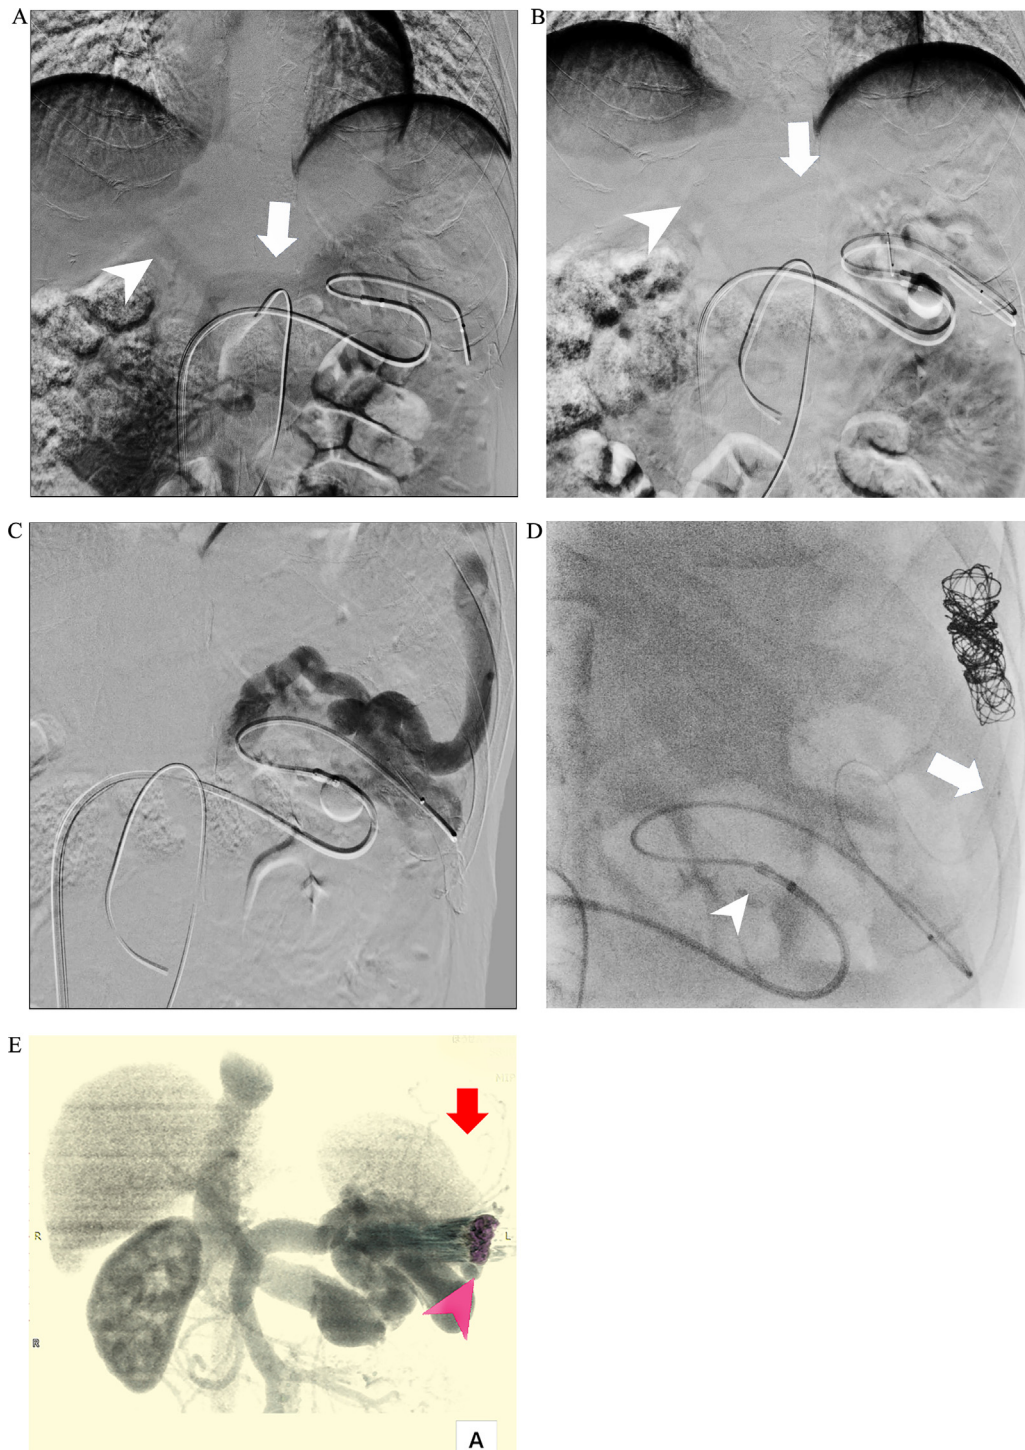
(A) Portography via the superior mesenteric artery (SMA) shows hepatofugal flow in the splenic vein (arrow) and portal vein (arrowhead). (B) SMA portography under balloon occlusion of the splenoportal (SR) shunt. (C) Balloon-occluded retrograde transvenous venography (BRTV) from the SR shunt. The 3 divided shunts shown in Fig. 1C are visualized. (D) Coil embolization of one of 3 shunts shown as (I) in Fig. 1C. Microcatheter was inserted (arrow) and 2-cm balloon was positioned in the SR shunt (arrowhead). (E) Volume-rendered images from abdominal dynamic CT after coil embolization. One of the 3 shunts (shown as (I) in Fig. 1C) has disappeared (arrow). Seven inserted coils are visualized (arrowhead).
